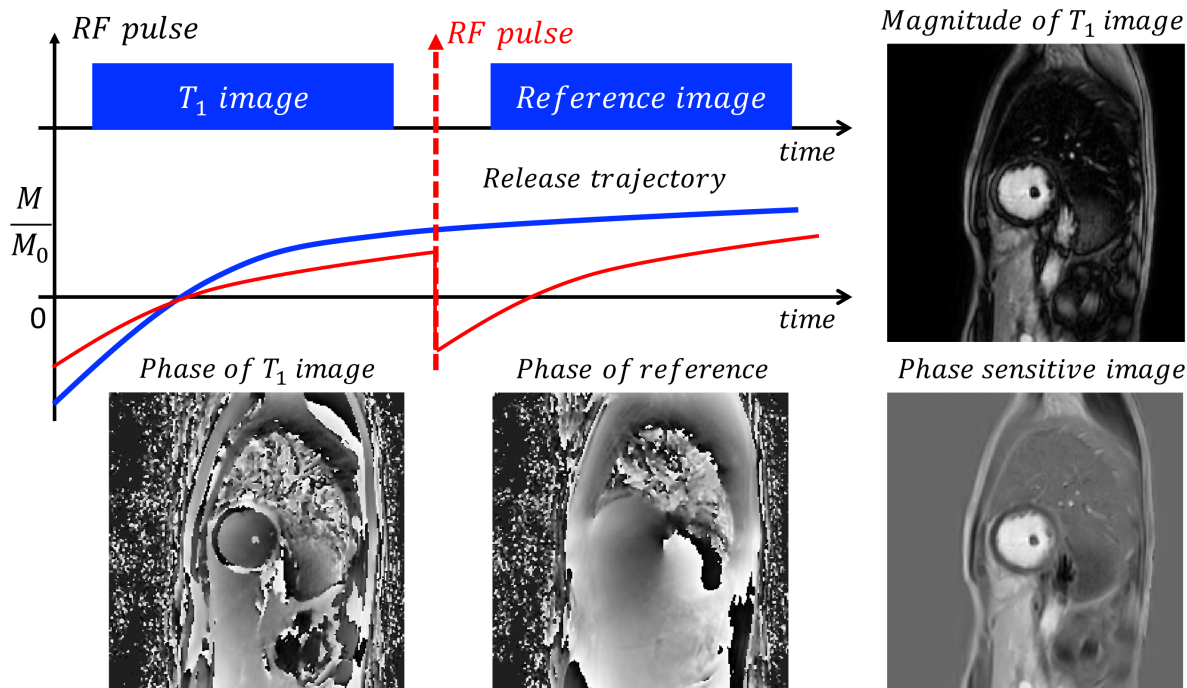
Phase sensitive reconstruction with a reference scan. A fully sampled reference scan was acquired to help remove the background phase of the T1 weighted image. Besides, this interleaved reference scan prolongs the release time and therefore allows the full recovery of MRI signal(blue line) compared with referenceless inversion recovery acquisition(red line)
